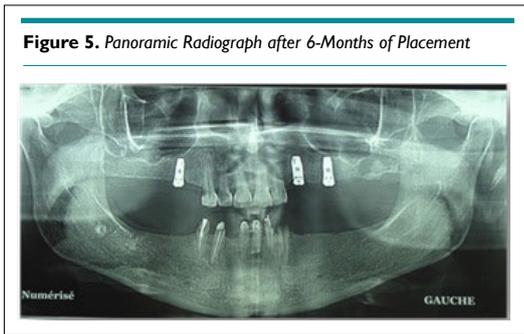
Panoramic Radiograph after 6-Months of Placement
